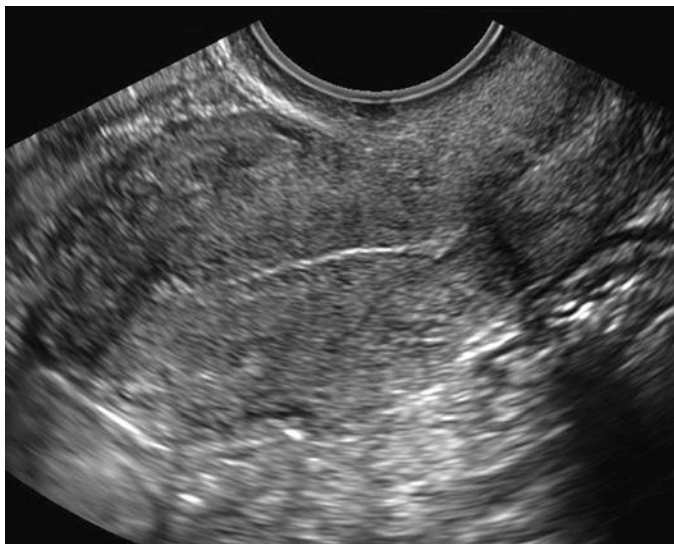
Longitudinal transvaginal sonography of the uterus shows a uniformly thin endometrial stripe measuring 1 mm in thickness. When adequately visualized, a thin endometrium less than 4 to 5 mm essentially excludes malignancy in a postmenopausal woman with vaginal bleeding.
